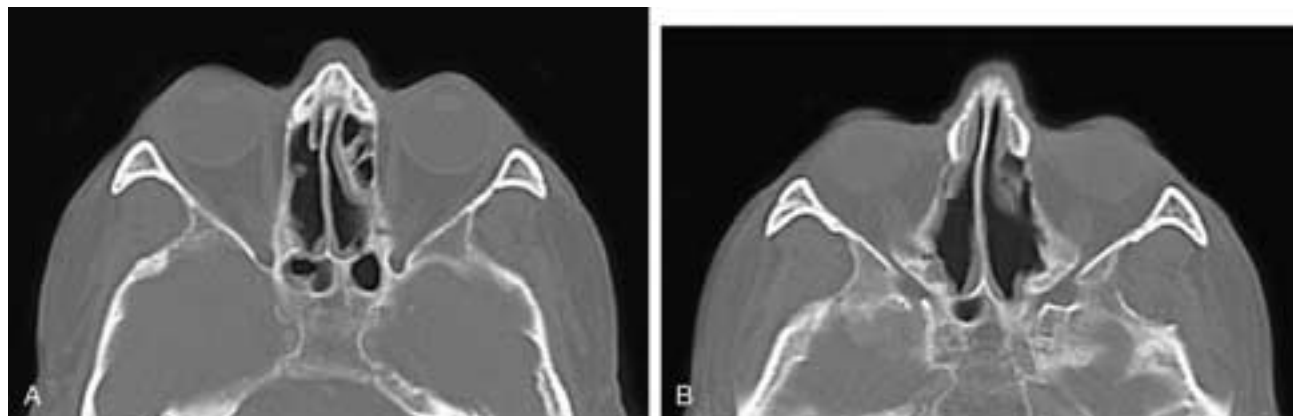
Axial CT scans at cranial (A) and caudal (B) levels of the ethmoid complex on a patient who has had bilateral internal ethmoidectomies. On the right side, almost all of the cells were removed. On the left side, the uppermost anterior cells remain. This appearance is typical of this operation, and the location of any remaining cells should be noted in the imaging reports of these cases.
